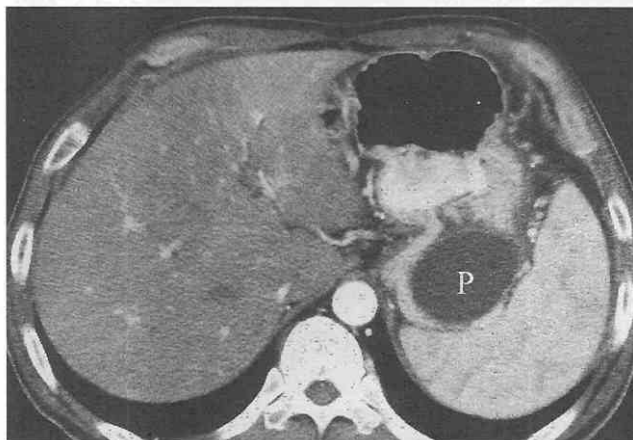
Gastric wall involvement in a patient with pancreatitis. CT scan shows a cystic mass (P) in the gastric wall due to extension of pancreatic pseudocyst.
